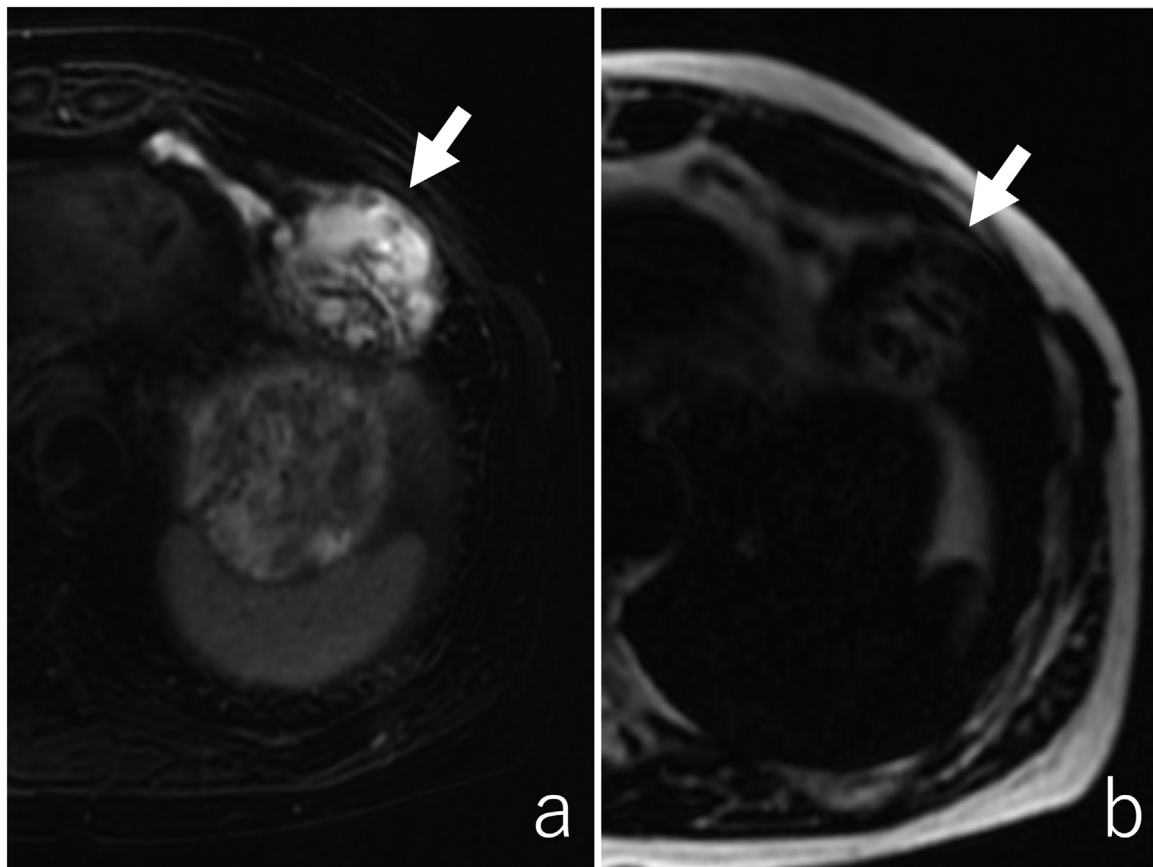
a) Magnetic Resonance Imaging revealed a septate cystic lesion with a high intensity on the T2-weighted image. b) Fat-suppressed T1-weighted images revealed that the mass contained less fatty tissue (arrows).
